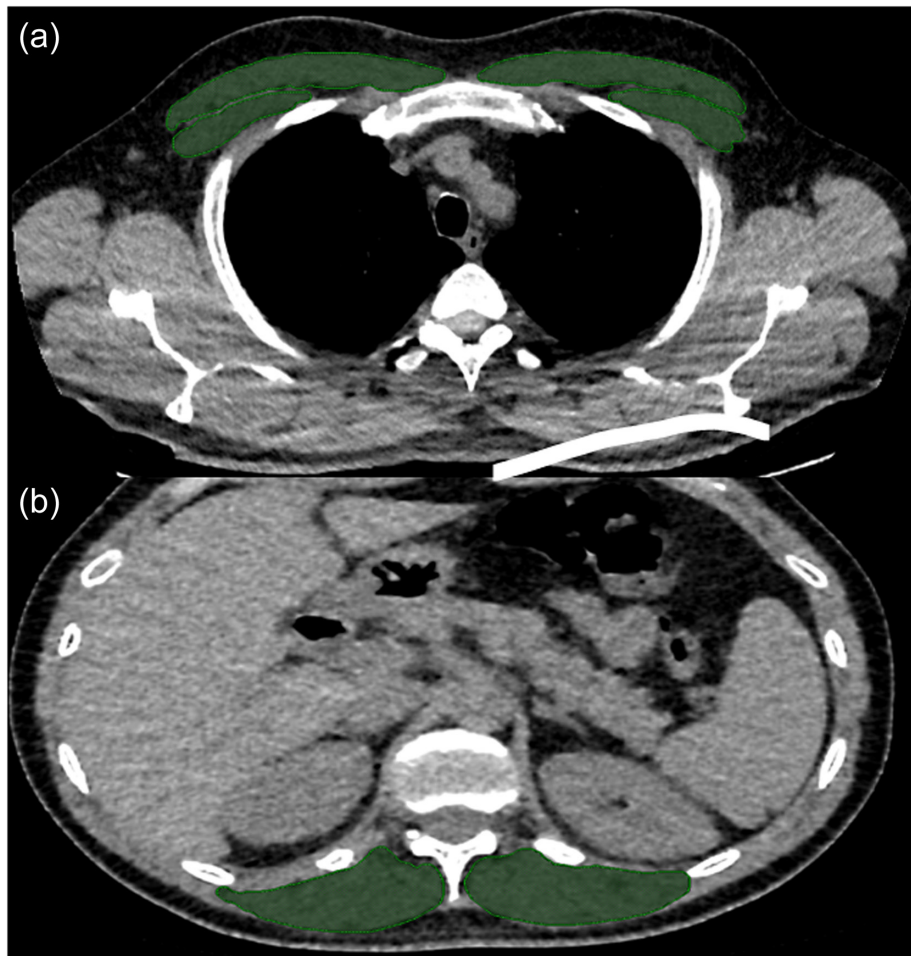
(A) Single-slice axial computed tomography (CT) images taken at the lower margin of the 12th thoracic vertebra to measure cross-sectional area and muscle attenuation of erector spinae muscle (ESM). (B) The quantitative analysis of the pectoralis muscle (PM) (pectoralis major and minor muscles) was applied on an axial slice just above the aortic arch. Bilateral muscles are colored green (ESM and PM).
